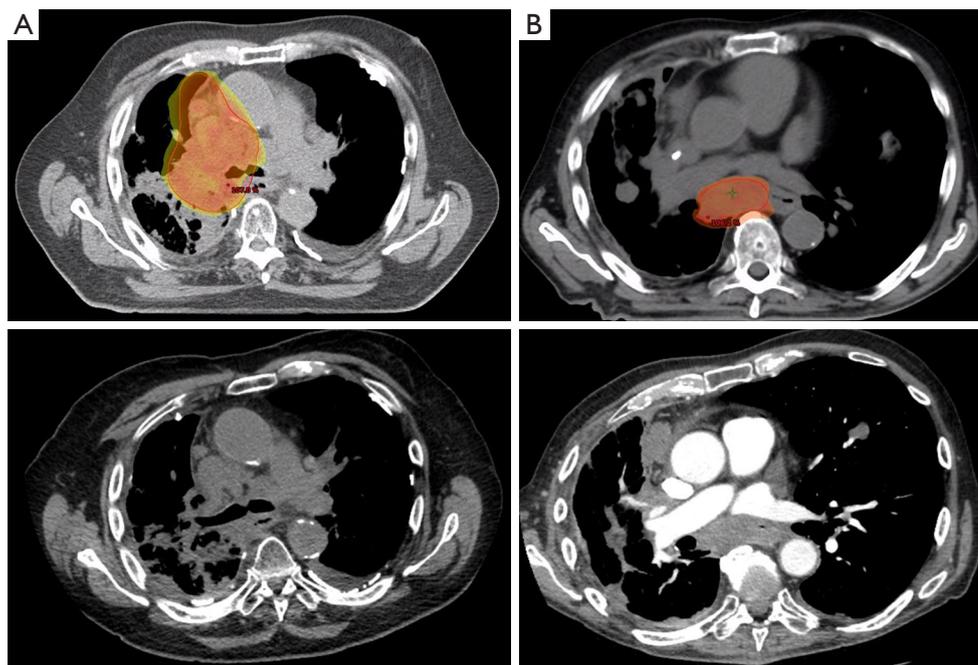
Tumor response following palliative radiotherapy. Representative axial chest computed tomography images of symptomatic radiotherapy targets (top) resulting in severe dyspnea due to right mainstem bronchial compression (A) and dysphagia due to esophageal compression (B). Tumor response (bottom) at 1 month following 20 Gy in 5 fractions (A) and 30 Gy in 10 fractions (B).
